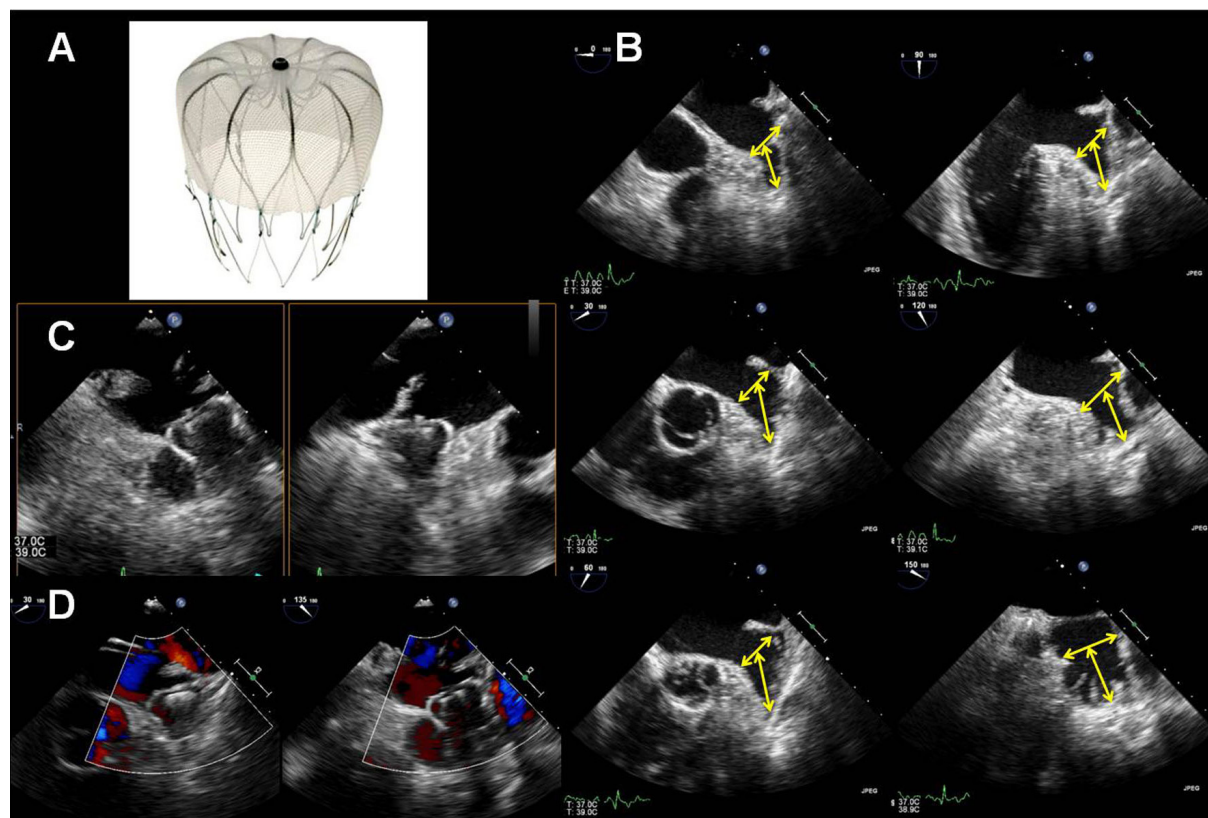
Percutaneous closure of left atrial appendage (LAA). The WATCHMAN™ device (Boston Scientific, Natwick, MA) is made of a self-expanding nitinol frame with fixation barbs and a permeable, polyester fabric covering, which is delivered through a sheath placed within the LAA (A). Pre-procedural transoesophageal echocardiography (TEE) is used to fully evaluate the diameters and the lengths of the LAA, using multi-plane 2D imaging for appropriate sizing of the device (B). Intra-procedurally, TEE is used to confirm the correct positioning and stability of the LAA closure device in multiple views (C). Importantly, colour Doppler TEE is used to show no residual blood flow around the margins of the device, confirming proper seal is achieved, before final deployment (D).
